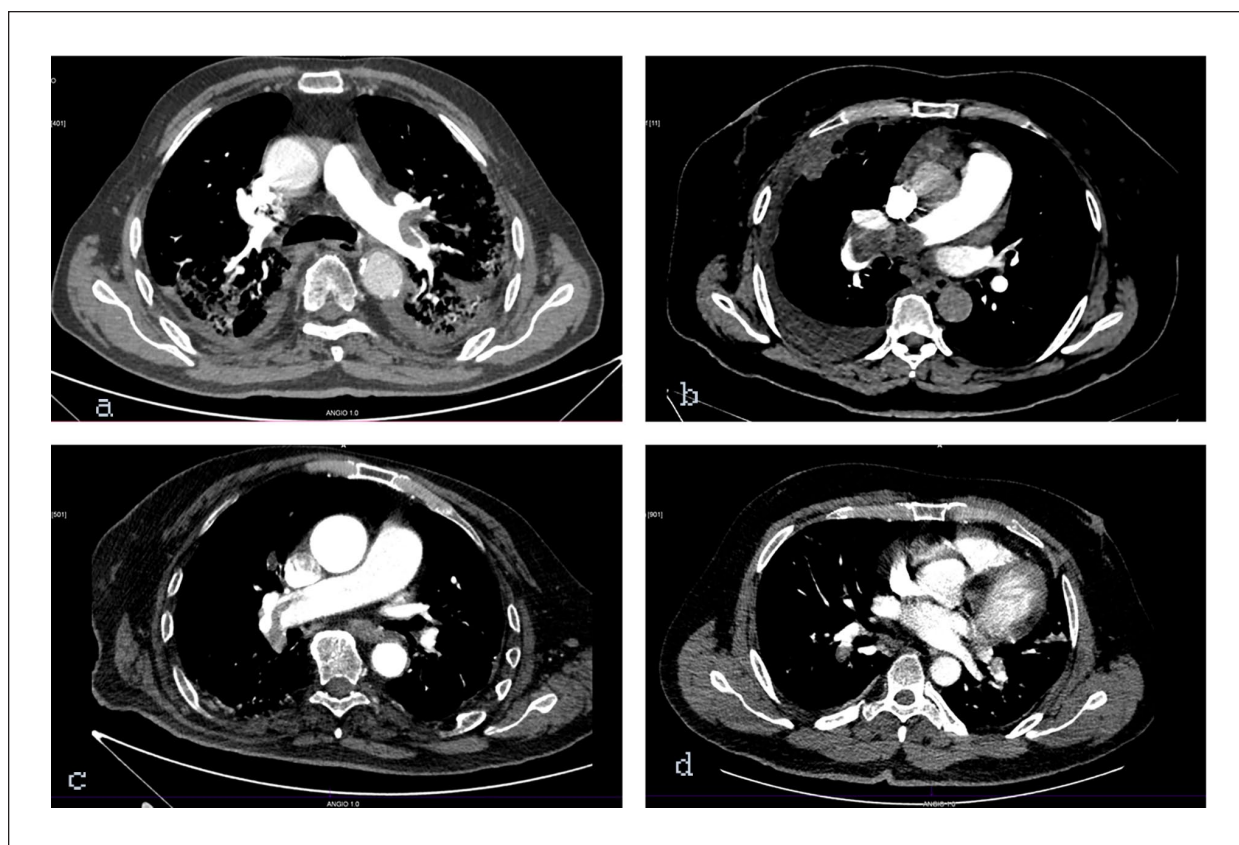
Representative CT pulmonary angiograms showing pulmonary emboli in COVID-19 patients in acute phase (a and b) of the disease and after overcoming virus infection (c and d).
